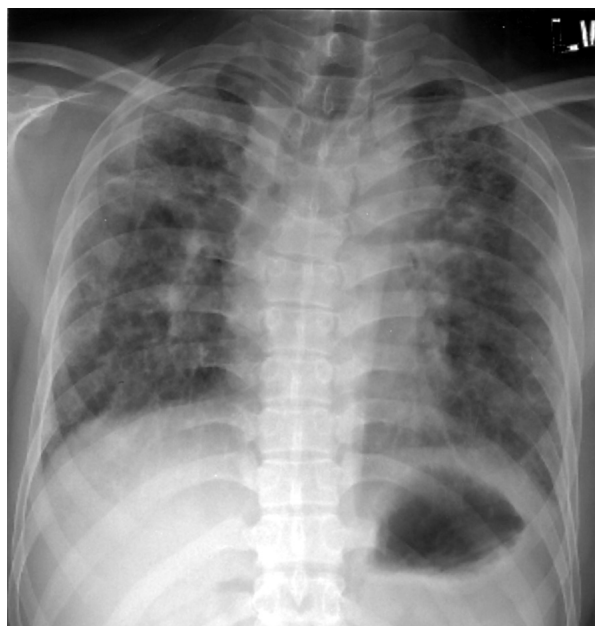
Chest radiography showing decreased lung volume and diffuse haziness interspersed with fibrotic bands over bilateral lung fields.
